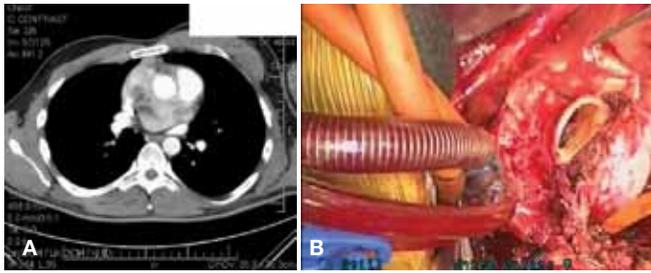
(A) CT scan showing aortic root paraganglioma; (B) surgical view after resection and aortic root reconstruction.
